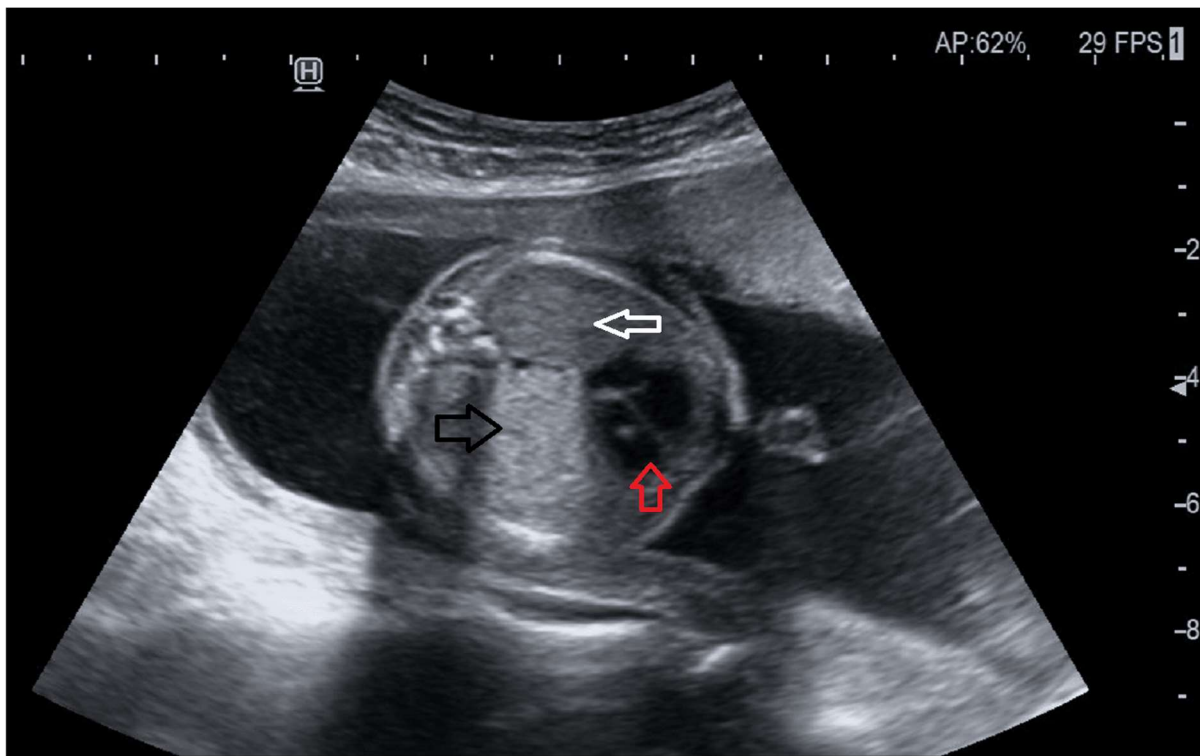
Transabdominal antenatal ultrasonographic axial section at the level of thorax showing asymmetric lung parenchyma, left lung appearing hyperechoic and large (black arrow) compared to right lung (white arrow) with mediastinal shift to the right side (red arrow)
